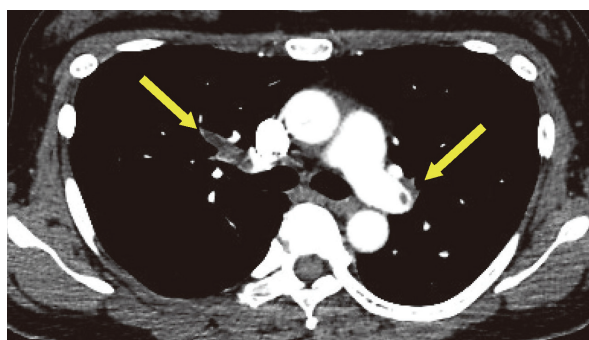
Computed tomography pulmonary angiogram revealing mass filling defects in several bilateral pulmonary artery segments (arrows)
